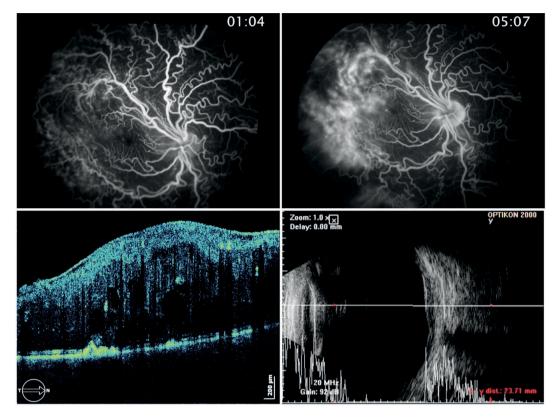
Ancillary diagnostic exams of the OD: A and B - Fluorescein angiography; B - OCT (Copernicus, SD-OCT); D - Ophthalmic ultrasound mode A+B.
